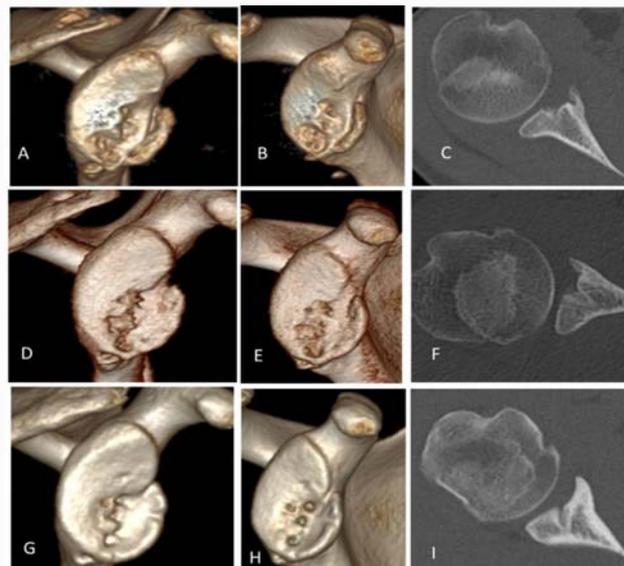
CT images at 3 months (A–C) at 6 months (D–F) and at 2 years (G–I). (A, D, G) Sagittal view; (B, E, H) Anterolateral view; (C, F, I) Axial view. The osseous Bankart lesion which had not been fully reduced was united at 3 months although osteolytic changes in the glenoid were observed. At 6 months to 2 years, peripheral flattening of the osteolytic lesion as a remodeling was noted.
